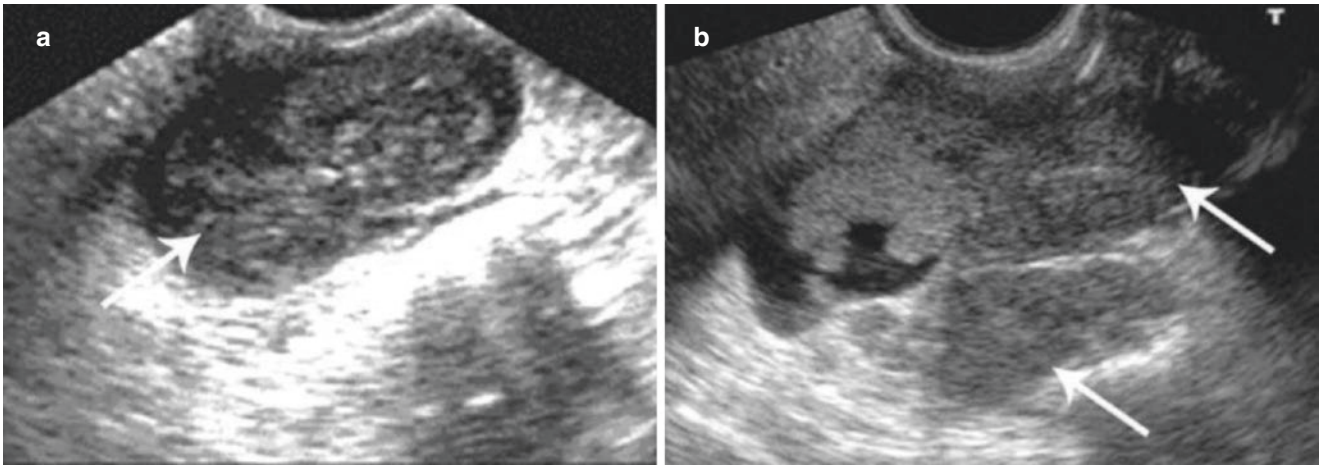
Recurrence of uterine leiomyosarcoma. (a, b) The patient underwent a hysterectomy for leiomyosarcoma half a year before. Multiple hypoechoic masses are detected in the pelvic and abdominal cavity by ultrasonography
